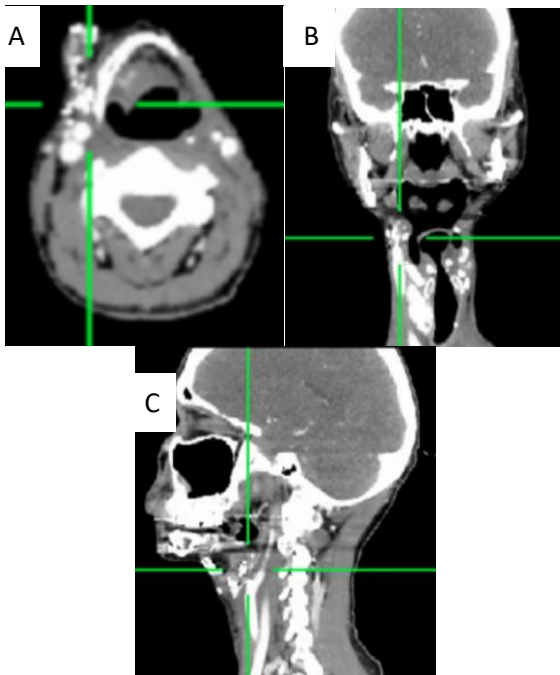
CT showing extensive metastatic process progression in the thyroid gland, with further spread retro-tracheal, para-oesophageal and bilaterally into the subcutaneous soft tissues of the neck.
